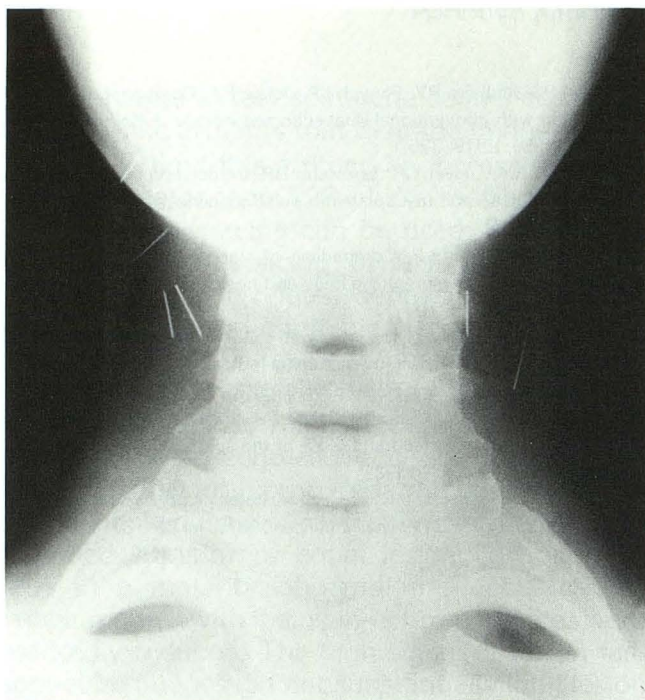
Soft tissue radiograph of the neck, anteroposterior view. Note the multiple broken needle tips bilaterally.
